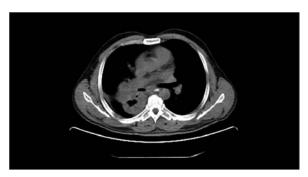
Computed tomography of the thorax shows a mass lesion that invades right pulmonary artery and pulmonary vein and occupies the right upper lobe.
